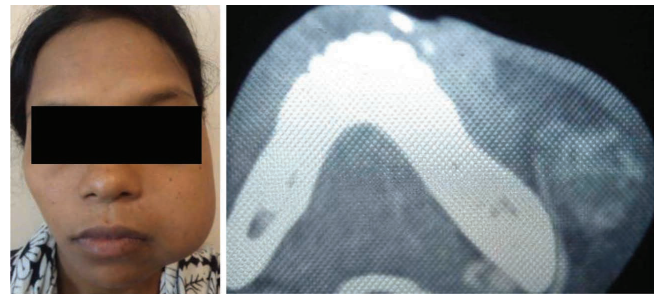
AVM of left cheek; Figure-2: CT scan showing AVM of patient No. 10
